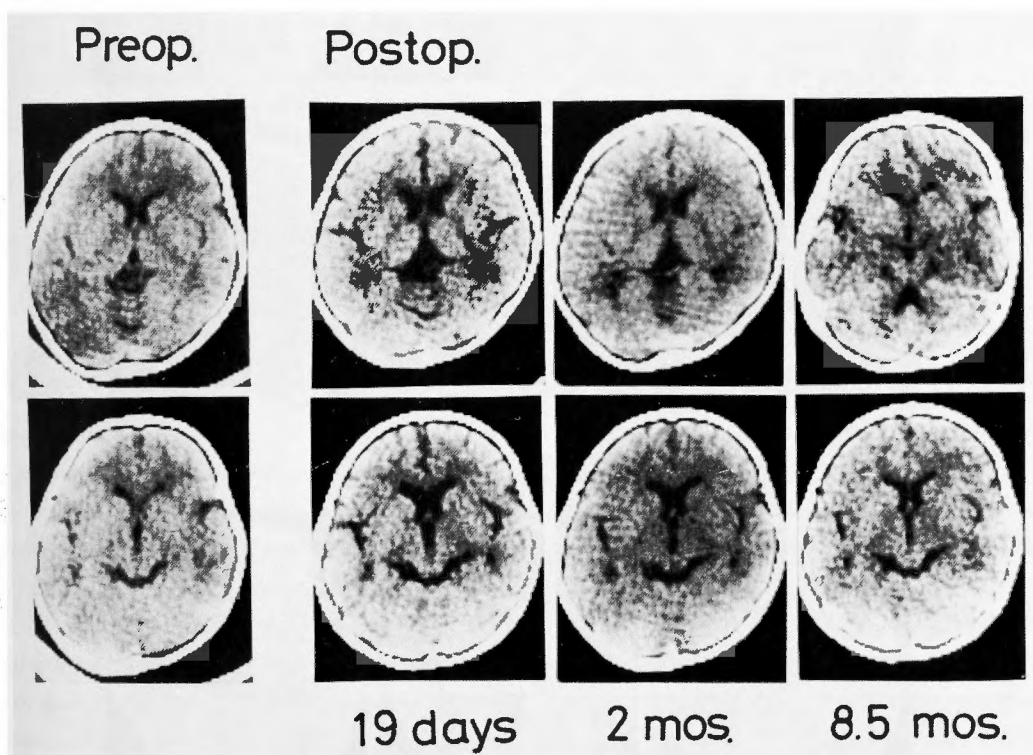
CT scans of the brain of a 2.7-year-old girl with tetralogy of Fallot who underwent total correction during 96 minutes of cardiopulmonary bypass with a bubble oxygenator; a 40 μ filter was in place in the arterial line. CT scans 19 days after operation showed mild-to-moderate enlargement of the internal and external cerebrospinal fluid space. CT scans 2 months after operation showed some improvements, and scans 8.5 months after operation showed recovery to the preoperative levels.
